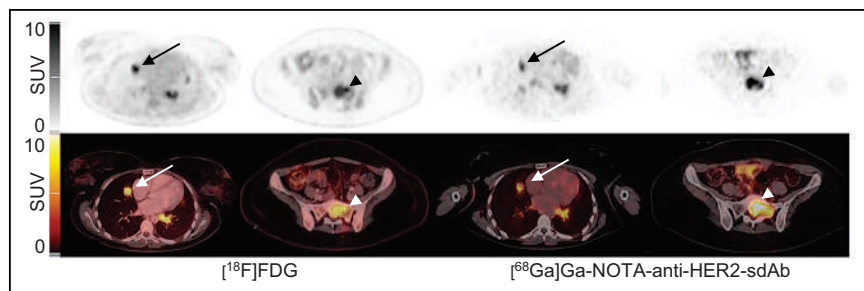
Patient 8 had bone (arrowhead), liver, and lung (arrow) metastases. SUV_{peak} with $[^{18}F]FDG$ in bone lesion (arrowhead) and in lung lesion (arrow) was 7.8 and 7.9, respectively. With $[^{68}Ga]Ga-NOTA-anti-HER2-sdAb$, SUV_{peak} was 10.7 and 5.6, respectively, indicating difference in uptake that was not seen with $[^{18}F]FDG$.
